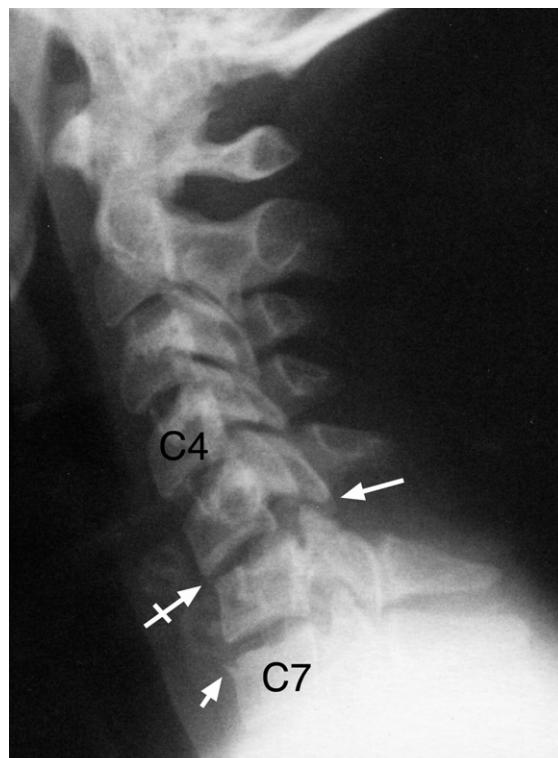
Cervical spine neutral lateral plain X-ray image. There is an angulation at the C5–6 level with loss of the normal cervical spine contour. In particular, note the subluxation of the C5–6 facets (long white arrow) with severe anterior wedging of the C5–6 disc that is narrower anteriorly (tailed white arrow). In addition, there was a degree of anterolisthesis of the C5 body on C6 and a small avulsion fracture of the anterosuperior margin of the C7 vertebral body (short white arrow).
